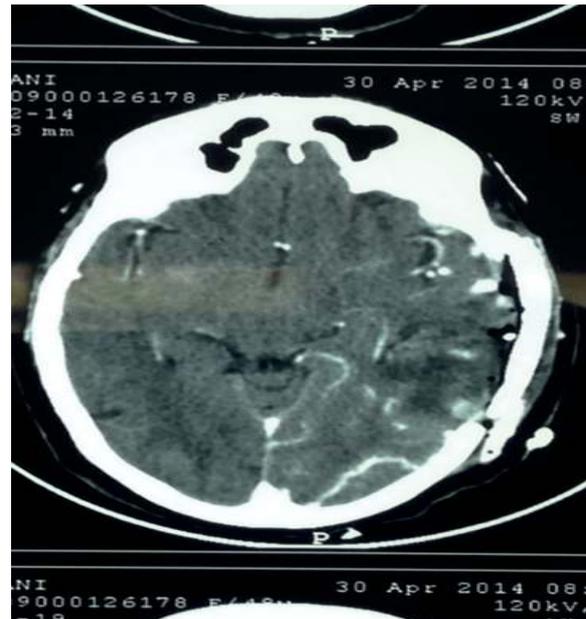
Post-Operative Contrast-CT showing complete excision of AVM.
